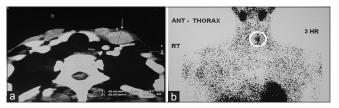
(a) Computed tomography scan showing a mass in the left lower part of the neck (white arrow); (b) Increased radiotracer uptake in 99m-technetium methoxyisobutylisonitrile scan at 3 h
